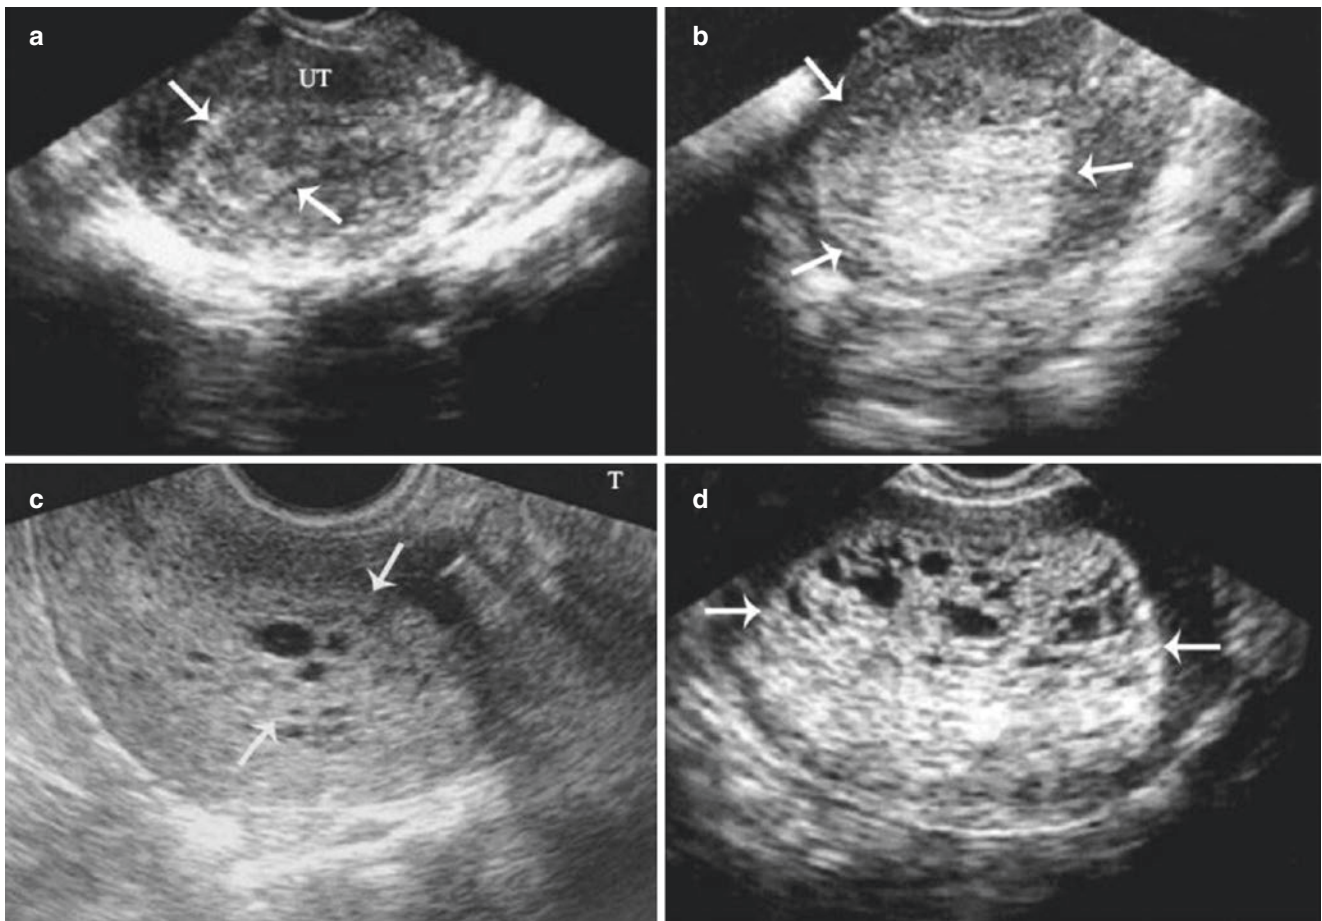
Endometrial carcinoma (II). (a) A 44-year-old patient with a history of menstrual disorder for half a year. Sonogram represents a thickened endometrium and heterogeneous echo. (b) A woman with a postmenopausal period of 10 years. Sonogram shows an enlarged uterus with thickened hyperechoic endometrium. (c) A woman with a
